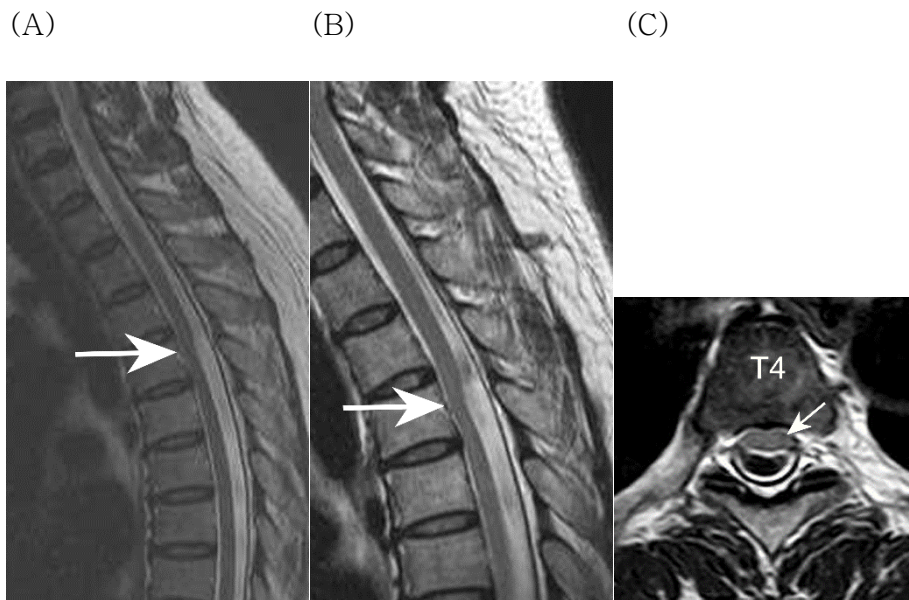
Lumbar and cervical spine MR of a 48-year-old woman who presented with low back pain. A. the sagittal T2-weighted image shows an asymmetric dented appearance and anteriorly displaced spinal cord at the T4 level. B, C. Follow-up cervical-spine MRI study four months after the first examination. The sagittal T2-weighted image (B) shows no interval change in cord deformity. The axial T2-weighted image (C) shows ventral displacement of the cord without focal spinal cord herniation and a relatively preserved anterior subarachnoid space at the T4 level. The arrow indicates the spinal cord.
